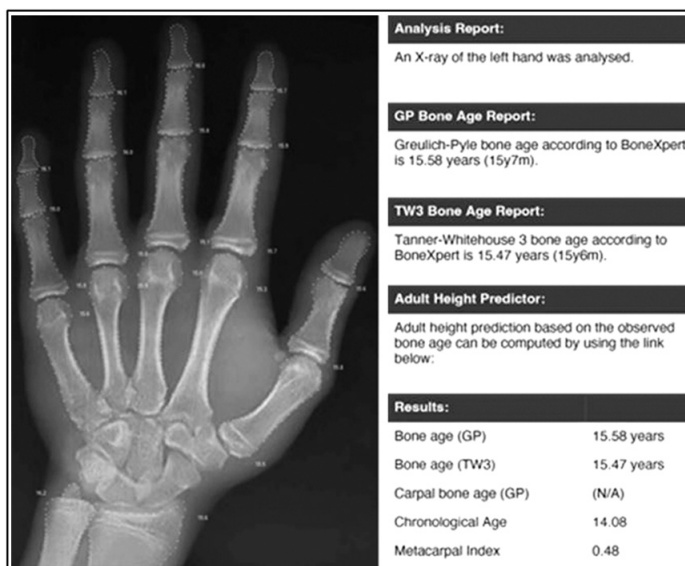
Bone age calculated from a radiograph of the patient's hand using the BoneXpert software at 12 months of surgery
